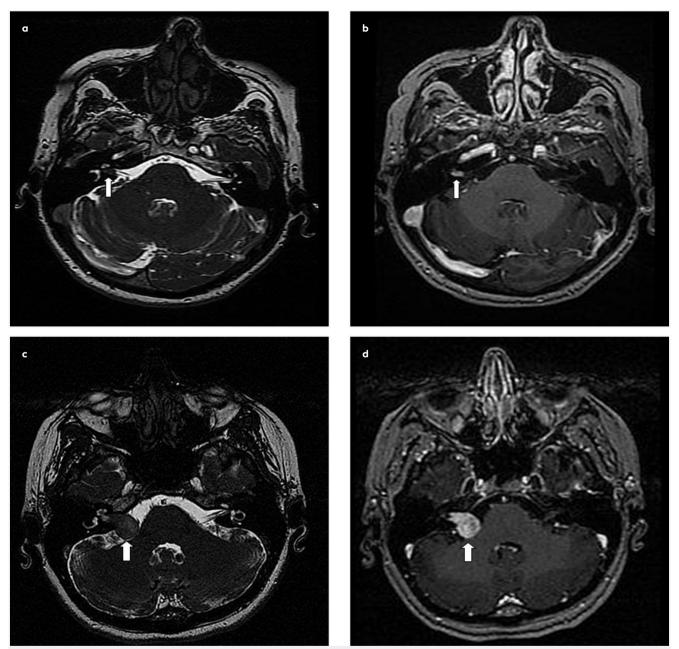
a-d. (a) Axial 3D FIESTA scan of temporal bone MRI showing a soft tissue filling defect in the right internal acoustic canal replacing the normal high-intensity perilymphatic fluid. (b) Postcontrast axial T1-weighted MRI in the same patient showing enhancement of this vestibular schwannoma (~ 8 × 5 mm) (white arrows). (c) Axial 3D FIESTA and (d) postcontrast axial T1-weighted scan of temporal bone MRI in another patient show vestibular schwannoma (~18 × 13 mm) extending from the right cerebellopontine angle through the internal acoustic canal (white arrows).
